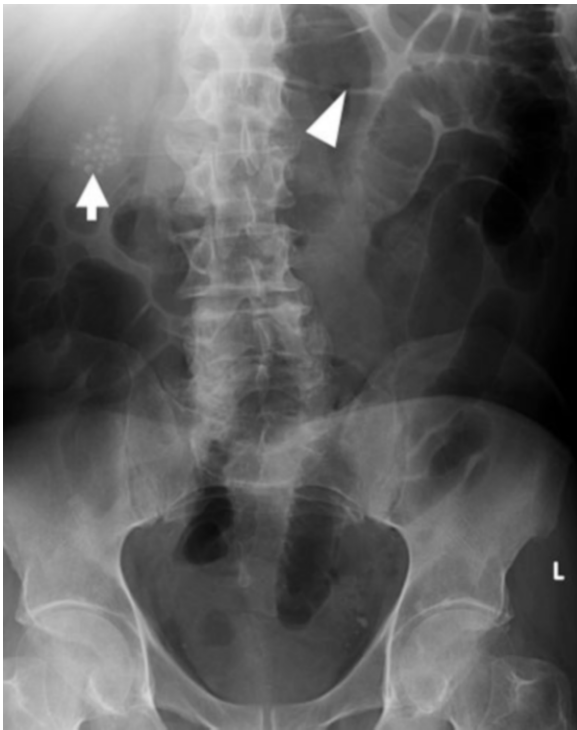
74-year-old man with Meckel's diverticulitis. Supine abdominal radiograph shows cholelithiasis (arrow) and dilated loops of small bowel (arrowhead)
